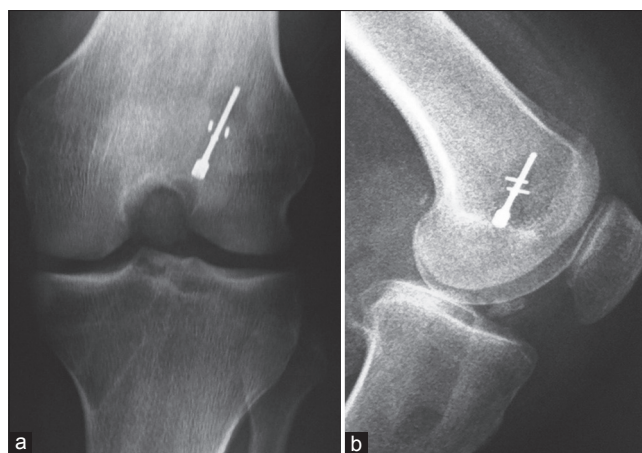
(a) Anteroposterior (b) lateral radiographs of the knee joint showing implanted AperFix system (Cayenne Medical, Inc., Scottsdale, Arizona, USA)
